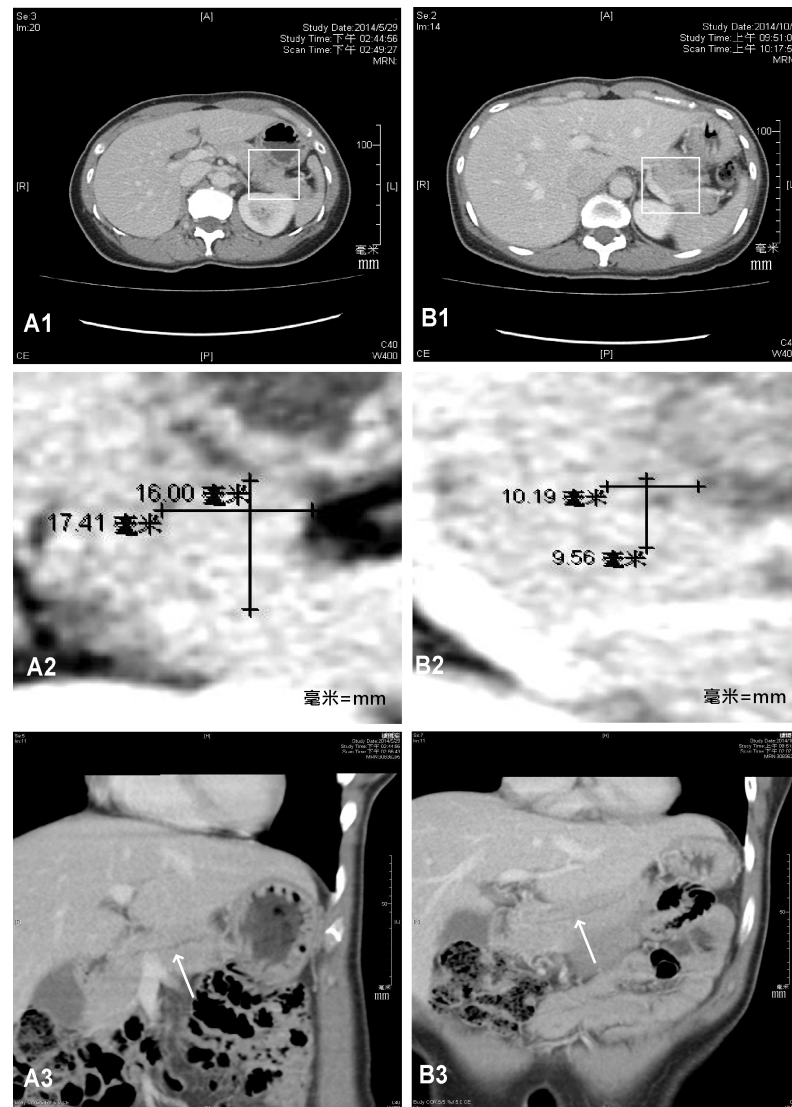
CT scan for suspicious pancreatic cancer IA of case 2. (A) CT scan on May 29, 2014. (A1) An isodense nodule in pancreatic tail (square area). (A2) Magnified photo of the square area of A1, showed the size of the isodense nodule about 1.6×1.7 cm. (A3) Dilated tortuous main pancreatic duct of the pancreas with diameter about 0.39 cm (arrow). (B) CT scan on October 6, 2014. (B1) The isodense nodule in pancreatic tail in the same position of the square area of A1. (B2) Magnified photo of the square area of B1 showed the size of the isodense nodule about 1.0×1.0 cm. (B3) Main pancreatic duct of pancreas with smooth feature about 0.14 cm in diameter (arrow). CT scan, computed tomography scan.
